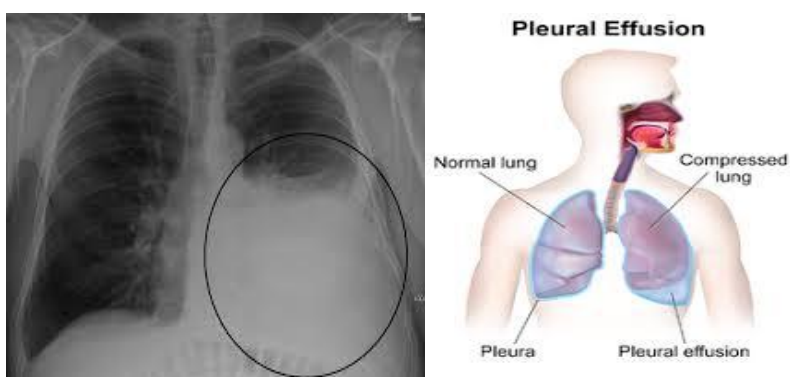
Pleural Effusion (Adopted from Dangila Primary Hospital X-Ray Room)
